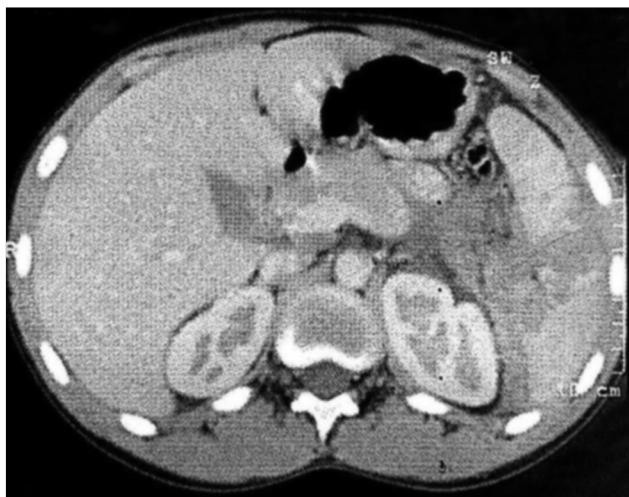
CT abdomen showing splenic injuries
